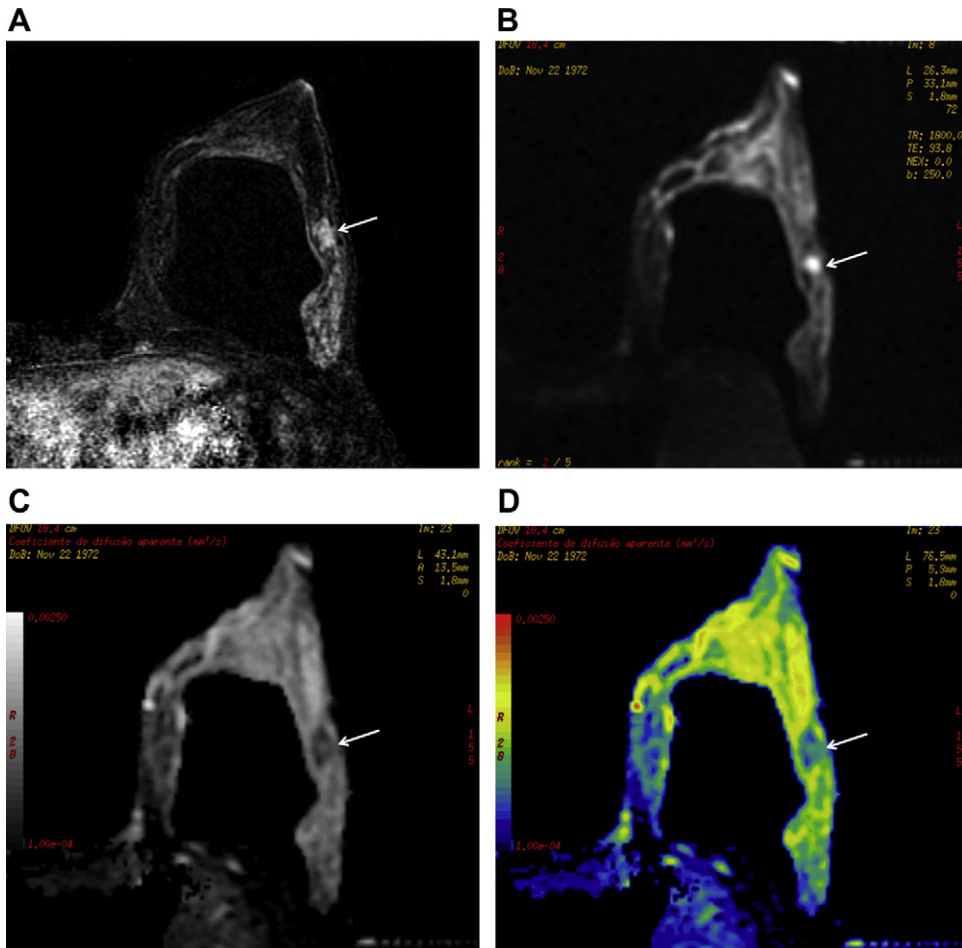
35-year-old woman with IDC of the left breast. (A) Axial contrast-enhanced T1-weighted three-dimensional spoiled gradient-echo image, in late phase. (B) Axial diffusion-weighted image. (C) Axial black-and-white and (D) colored ADC maps obtained using b-values of 0 and 750 s/mm^2 reveal a 1.1-cm mass (white arrows) classified as probably benign by conventional MR imaging. Note the low signal on the ADC black-and-white map and the blue on the ADC colored map, which indicates a malignant lesion.
